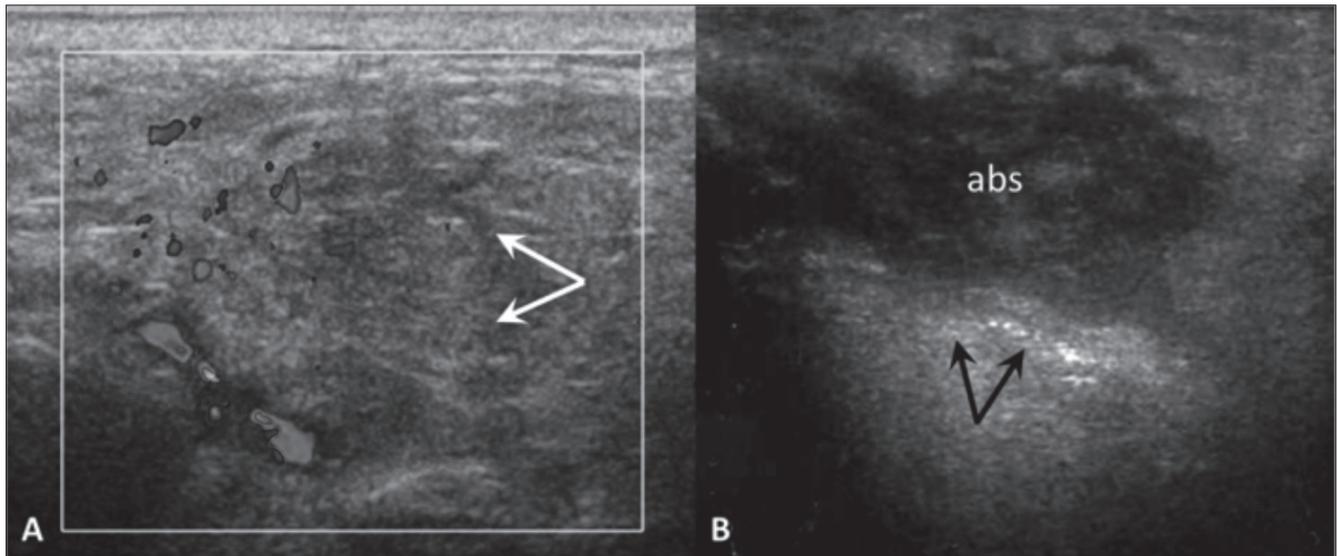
Acute parotid sialadenitis (A). Enlarged, hypoechoic parotid gland (arrows), colour Doppler shows increased blood flow. Parotid gland abscess (B). US demonstrates a heterogeneous hypoechoic collection (abs) within the parotid gland: internal echoes, poorly defined borders and posterior acoustic enhancement (arrows).
